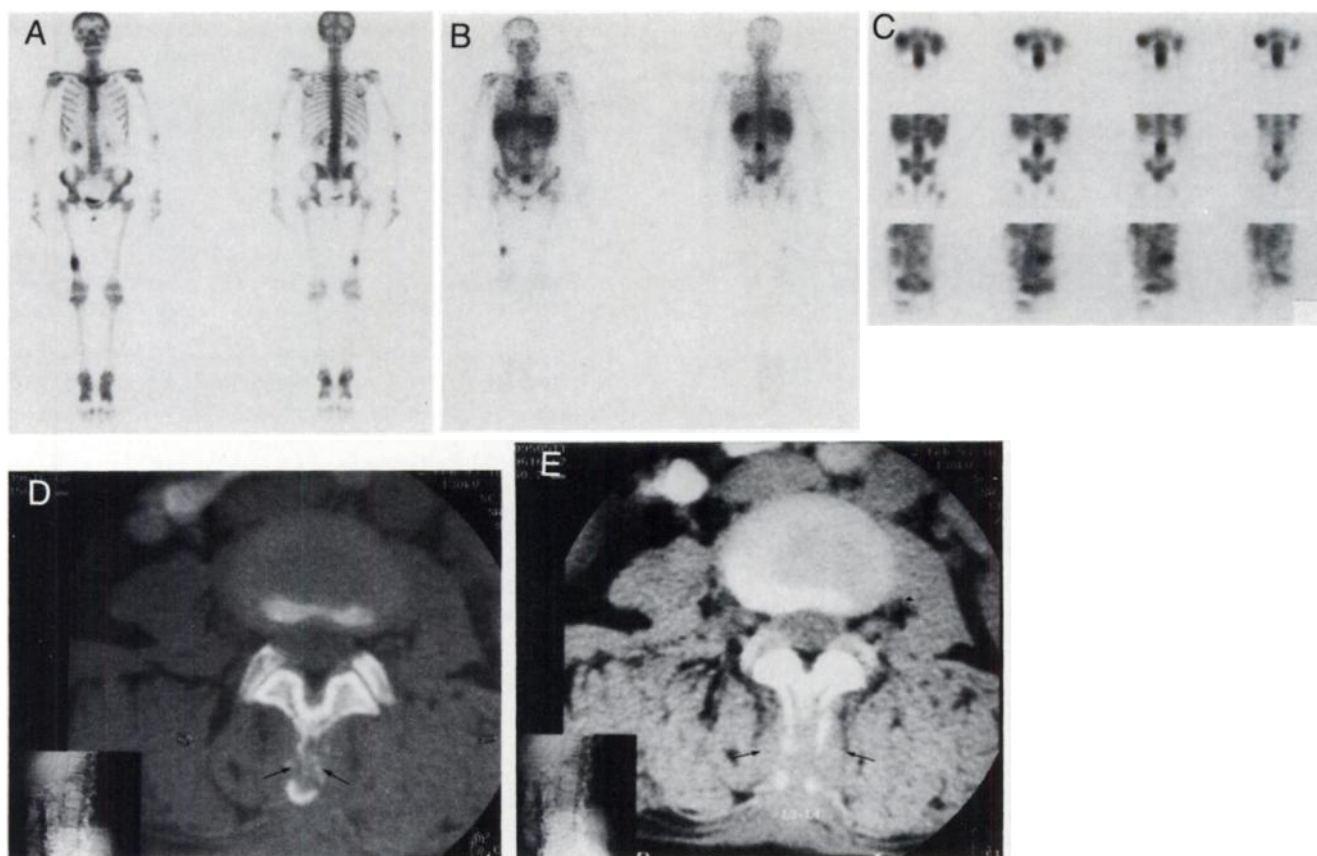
Gallium-67 and bone scintigraphy in a 39-yr-old female with diffuse large-cell immunoblastic lymphoma who complained of low back pain a short time after completing chemotherapy with Promace/MOPP. (A) Bone scintigraphy shows only slight abnormal uptake in the L-3 vertebra and the distal third of the right femur. (B) Planar ^{67}Ga scintigraphy shows intense abnormal uptake in the L-3 vertebra and abnormal uptake in the right femur and sacrum. Pathological uptake in the mediastinum is also shown. (C) Gallium-67 SPECT images in the transaxial, coronal and sagittal sections shows the lesion in the spinous process of L-3. CT at the level of the third lumbar vertebra using bone (D) and soft-tissue (E) windows shows symmetric lysis of the spinous process and a bilateral, paravertebral soft-tissue mass (arrows). CT (not shown) also confirmed the lesions shown on ^{67}Ga scintigraphy in the femur, sacrum and mediastinum.
